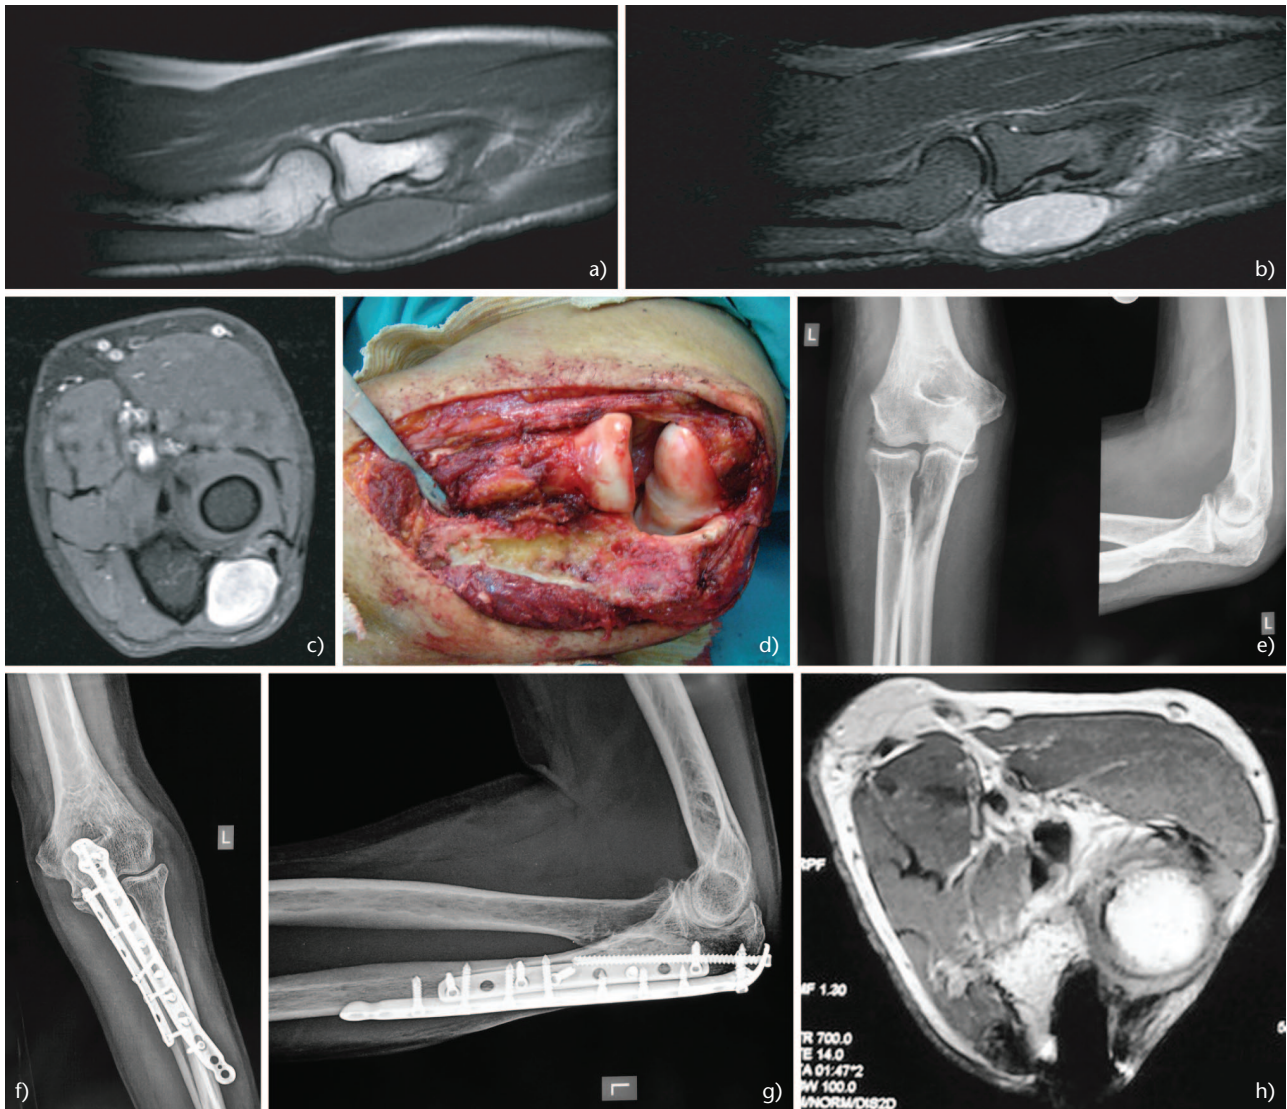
A 64-year-old man presented with a small painful mass of his left elbow. (A) Sagittal T1-weighted magnetic resonance imaging (MRI) showing a well-circumscribed mass with homogenous intensity. (B) Sagittal T2 Short Tau Inversion Recovery (STIR) MRI. (C) Axial T1 fat saturated contrast MRI. (D) Intra-operative image following wide excision of the tumour, including the proximal part of the ulna attached to the tumour. The biopsy confirmed the diagnosis of synovial sarcoma. (E) Post-operative radiographs after tumour resection. However, a pathological fracture of the proximal ulna occurred secondary to radiation therapy. (F) Anteroposterior and (G) lateral elbow radiographs following open reduction and internal fixation of the pathological fracture of the ulna with two plates. (H) Post-operative axial T1 MRI with contrast showing no signs of recurrence three years post-operatively.
